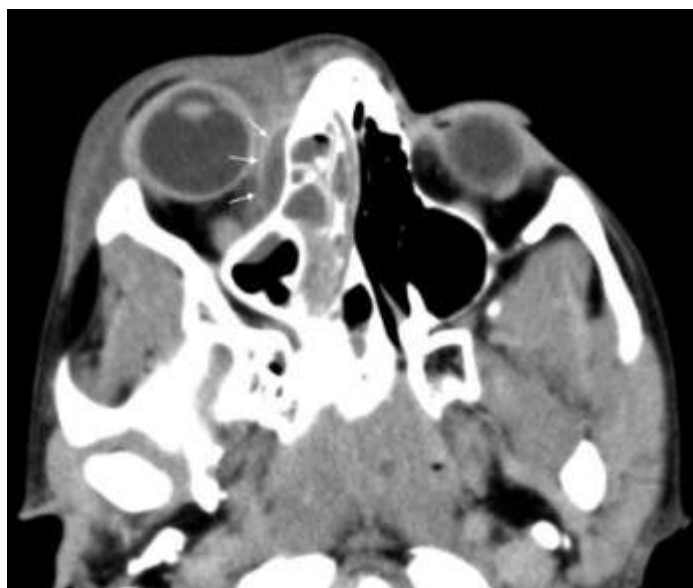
CT PNS (axial cut) showing Subperiosteal abscess
